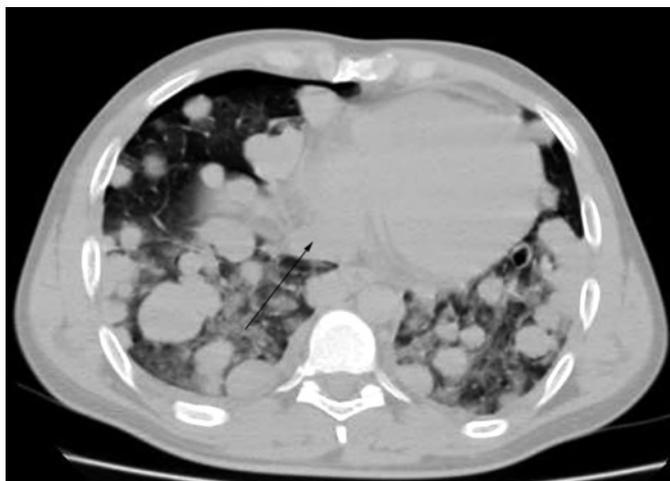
Chest CT scan shows bilateral diffuse nodular infiltrates ranging from 5 mm to 4 cm with normal heart size.
